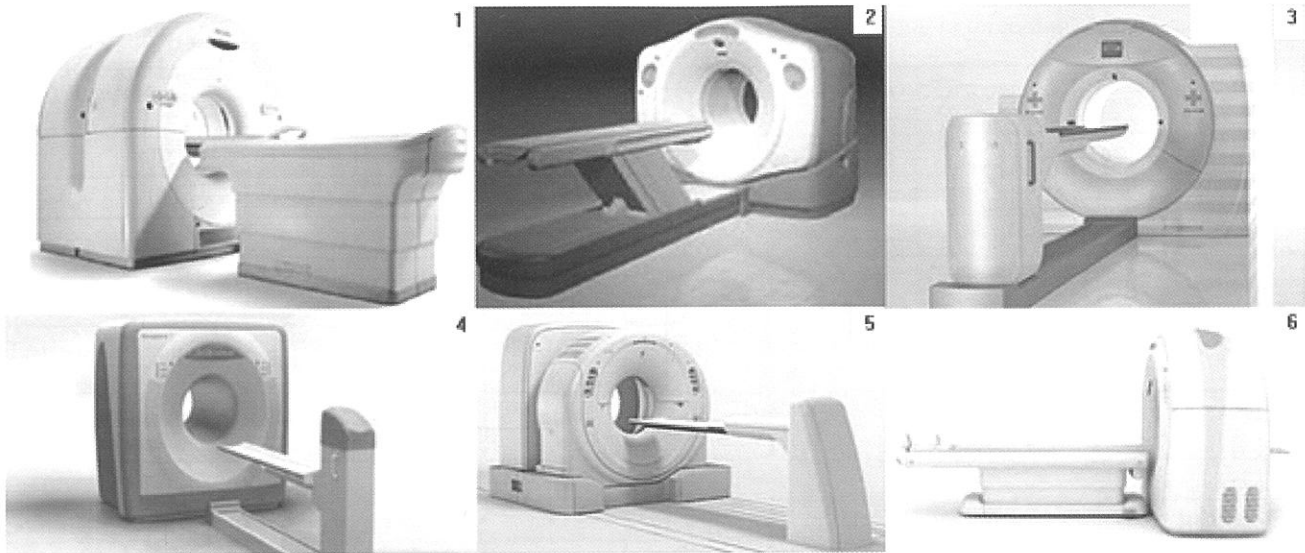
Current commercial PET/CT systems: (1) Gemini series from Philips Healthcare, (2) Discovery series from General Electric Healthcare, (3) Biograph mCT from Siemens Healthcare, (4) Sceptre series from Hitachi Medical Systems, (5) Acquiduo series from Toshiba Medical Systems, (6) Anyscan from Mediso (this device can be combined with a SPECT to form a triple-modality imaging system [14]).
